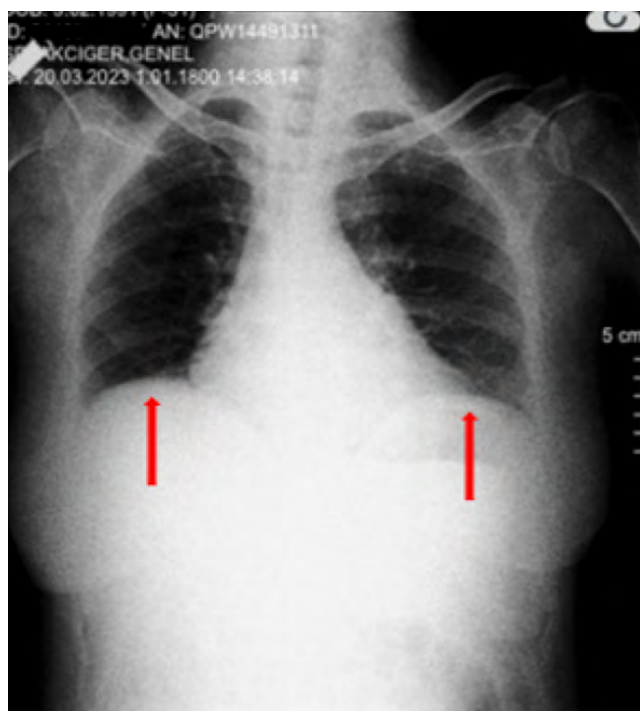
Posteroanterior chest X-ray. Bilateral diaphragm elevation and reduced lung volumes in lower lobes.
